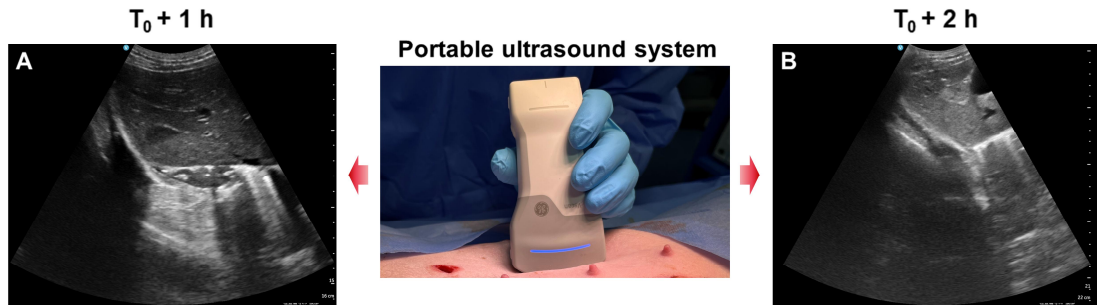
Examination of the injured area for further active hemorrhage using a portable ultrasound system: (A) Ultrasound image 1 hour after injury creation ($T_0 + 1$ h). (B) Ultrasound image 2 hour after injury creation ($T_0 + 2$ h).
